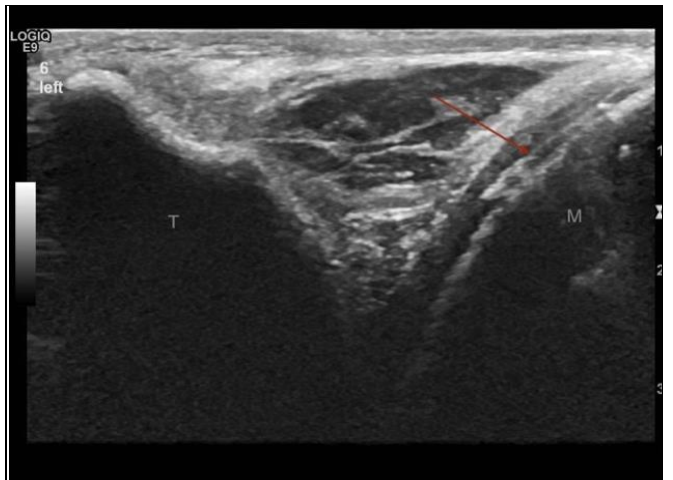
Ultrasound image of the needle in the DMJ. Red arrow pointing to the needle in the intraarticular space of the DMJ. T stands for Temporal bone and M stands for Mandibular condyle.
